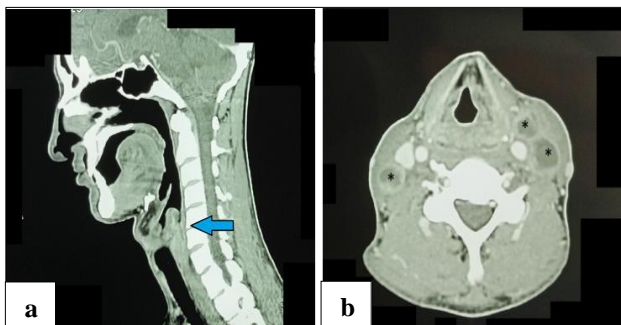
(a and b): CT scan of the neck showing multiple enlarged necrotic cervical lymph nodes, the largest measuring 1.4×1.4 cm (right level IIB) and 1.4×1.7 cm (left level IIA), with an asymmetrical bulky left aryepiglottic fold and a hypodense lesion in the post-cricoid region.
